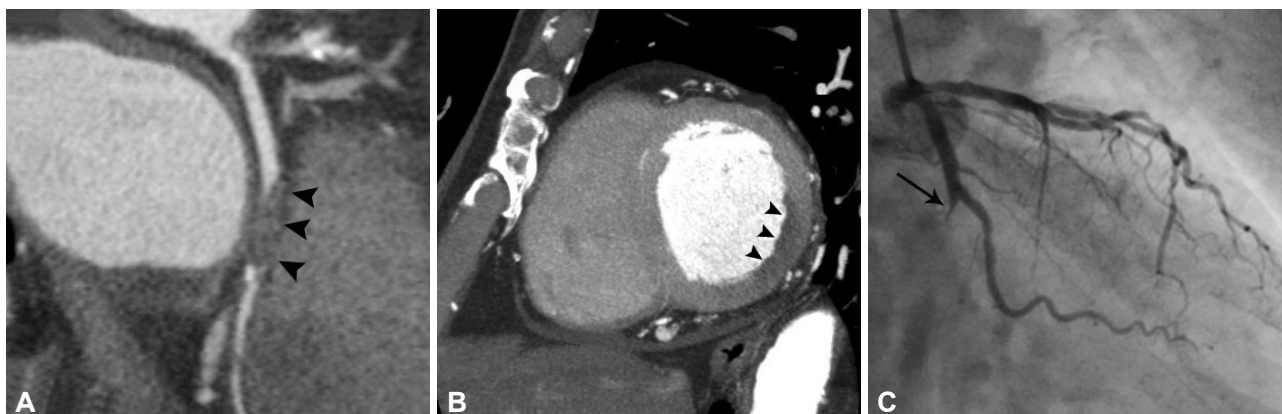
Diagnostic delay in a 66-year-old male patient with acute coronary syndrome. The patient presented with acute chest pain. Dedicated coronary CT angiography was performed 7 days after symptomatic onset because the attending physician did not consider acute coronary syndrome as a primary diagnosis. A: curved multi-planar reformatted image shows total occlusion of distal left circumflex coronary artery (arrowheads). B: short axis curved multi-planar reformatted image at the basal level of the left ventricle demonstrates perfusion defect with low attenuation (arrowheads) in the territory of the left circumflex coronary artery. C: coronary angiogram shows complete obstruction (arrow) at the origin of distal left circumflex coronary artery.
